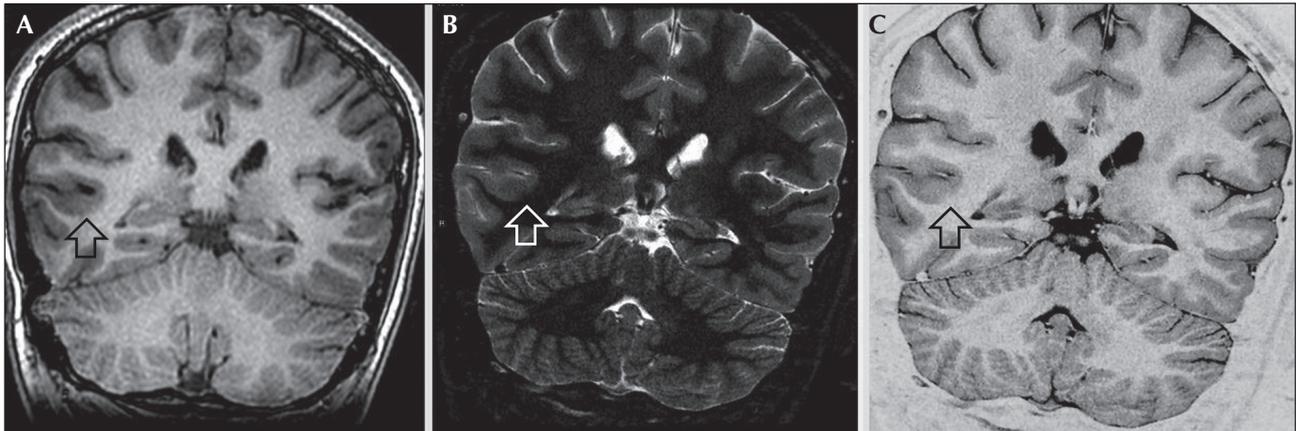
(A) Coronal T1-weighted peri-ictal MRI multiplanar (MPR) reconstruction, (B) coronal thin-slice inversion recovery (IR), and (C) coronal thin-slice FSE T2 image of the patient whose previous MRI had been considered normal. Note the focal area of slightly thickened cortex and blurred cortical-subcortical junction in the posterior section of the right temporal lobe; 1-mm thin sections are suggestive of cortical dysplasia.
